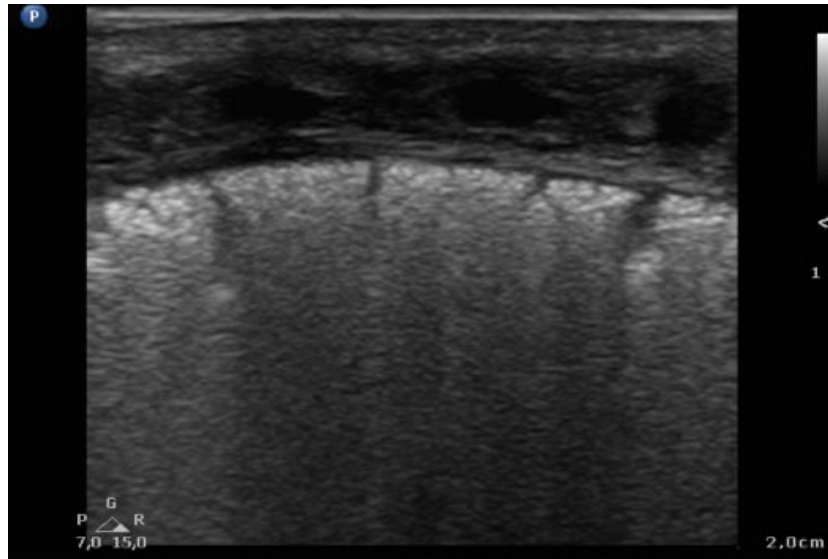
Representative Lung Ultrasound Findings by Diagnosis
